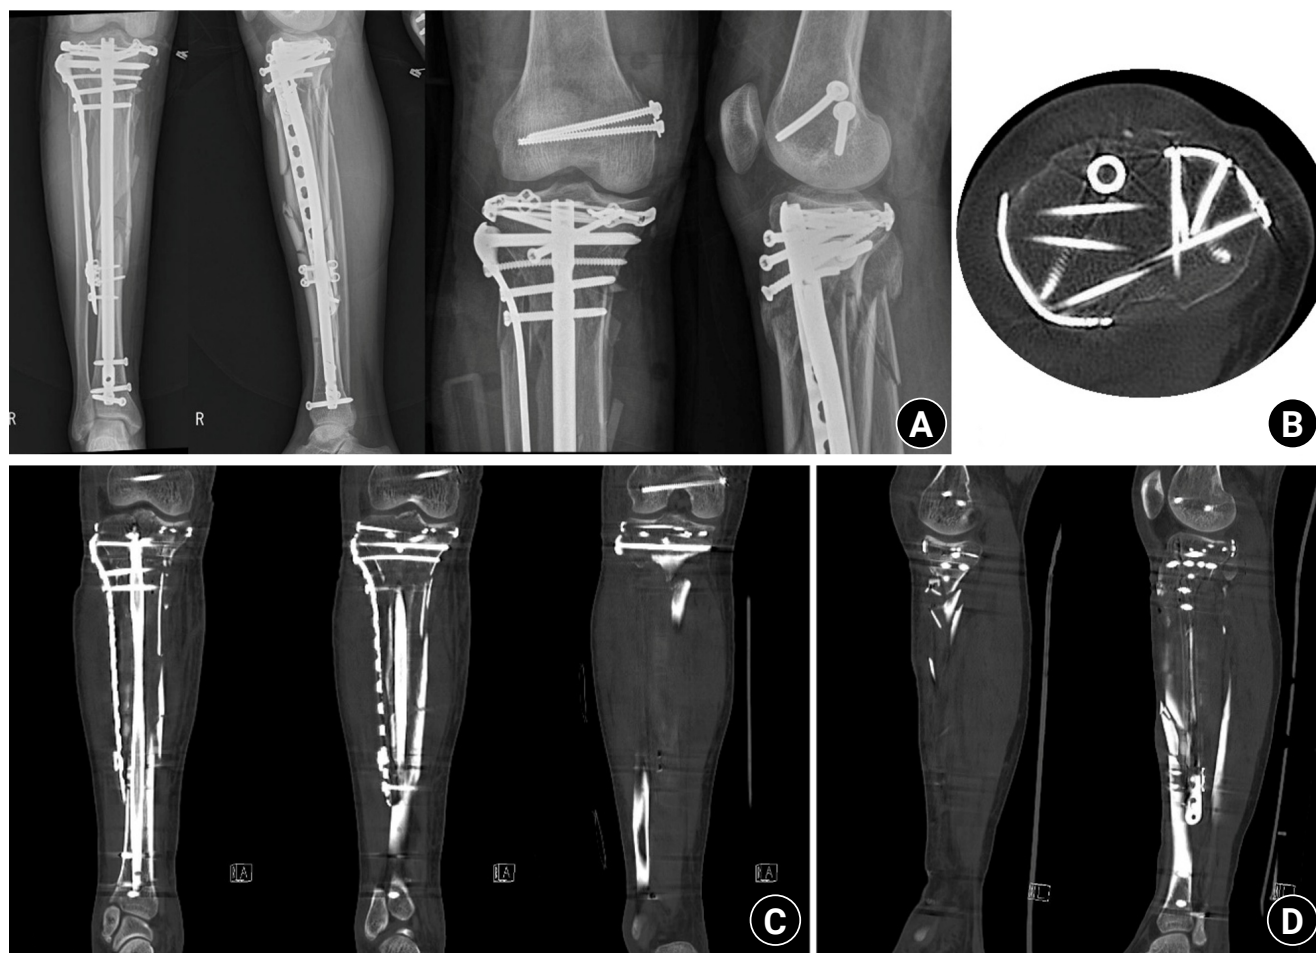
Postoperative plain radiographs and computed tomography (CT) images. (A) Postoperative plain radiograph. (B) Axial CT image confirming that screws from the rim plate did not interfere with the intramedullary nail trajectory. (C) Coronal CT image after fixation. (D) Sagittal CT image after fixation.
